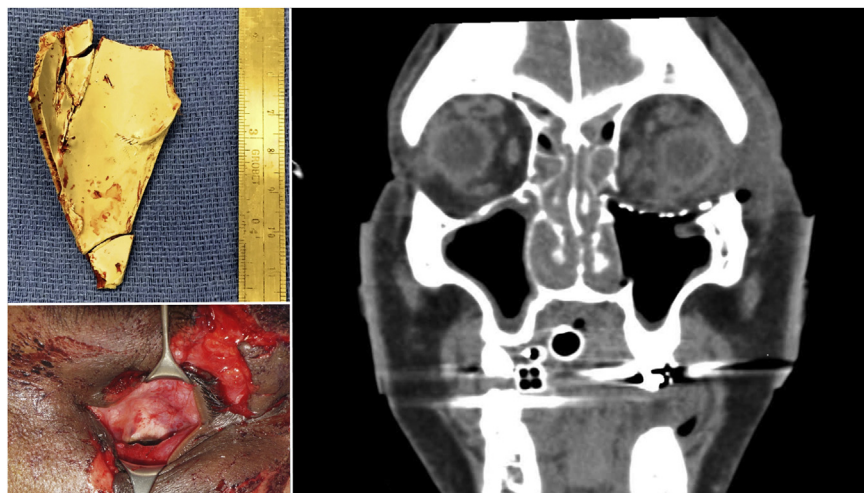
Clockwise from top left. The foreign body was found to be approximately 4 cm × 7 cm in size. Post-operative coronal view of non-contrast computed tomography (CT). Intraoperative view of inferiorly displaced globe.
